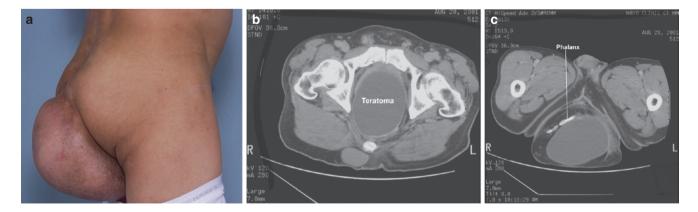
(a) Massive cystic teratoma with sacral appendage. (b) CT of intrapelvic portion. (c) CT of extrapelvic portion with fully developed phalanx. (Reused with permission of Mayo Foundation for Medical Education and Research, all rights reserved)
